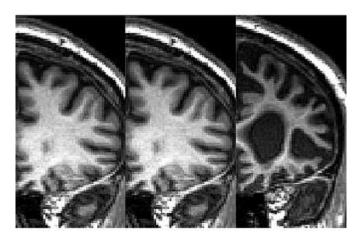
MRI evidence of escalating atrophy of orbitofrontal cortex in frontotemporal dementia
